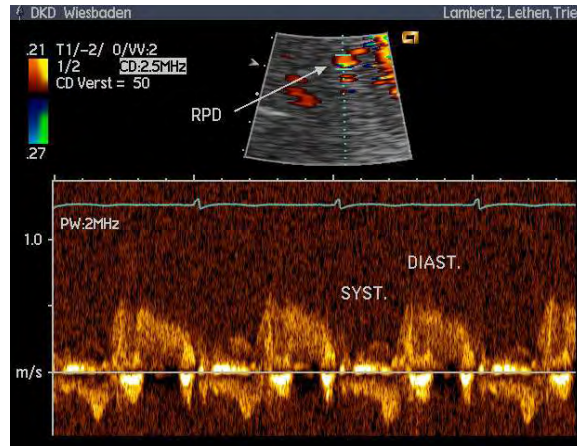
Characteristic biphasic spectral Doppler recording of coronary blood flow velocity in the distal RCA (Heinz Lambertz et al., 2004).
